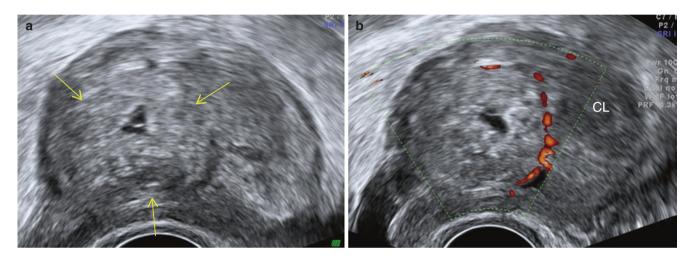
A case of ovarian ectopic pregnancy. (a) The ovary is enlarged and shows a poorly defined circumscribed hyperechoic area suggestive of trophoblastic tissue (between *arrows*). Within this, a tiny cystic area suggestive of a gestational sac is seen. A small yolk sac is seen within. Ovarian tissue is seen around the ectopic pregnancy tissue. (b) Minimal peripheral flows seen on power Doppler around the trophoblastic tissue. A corpus luteum (*CL*) is seen just beside the ectopic pregnancy tissue in the same ovary. Beta hCG in this case was 2600 mIU/mL
